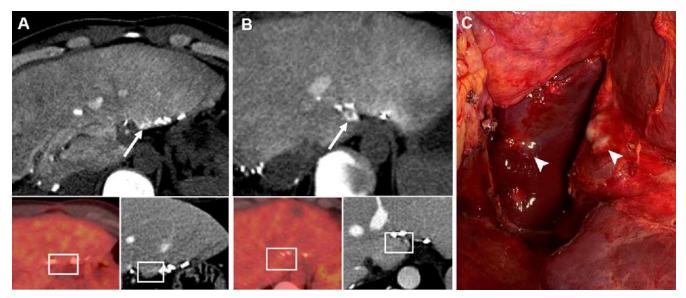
Images in a 42-year-old woman who presented with two small incidental RHLMs (both sizes: 5 mm) found at CTHA during ablation; the RHLMs were confirmed to be colorectal liver metastases by subsequent surgery. (A, B) Preprocedural axial CTHA images in late arterial phase show two incidental RHLMs (arrows), near the surgical clips, which were not detected at PET/CT and axial CT in portal venous phase performed 1 day and 9 days before the ablation, respectively (insets). (C) Intraoperative image shows two necrotic tumors in correspondence with the incidental RHLMs (arrowheads). CTHA = CT during hepatic arteriography, RHLM = ring-hyperenhancing liver micronodule.
